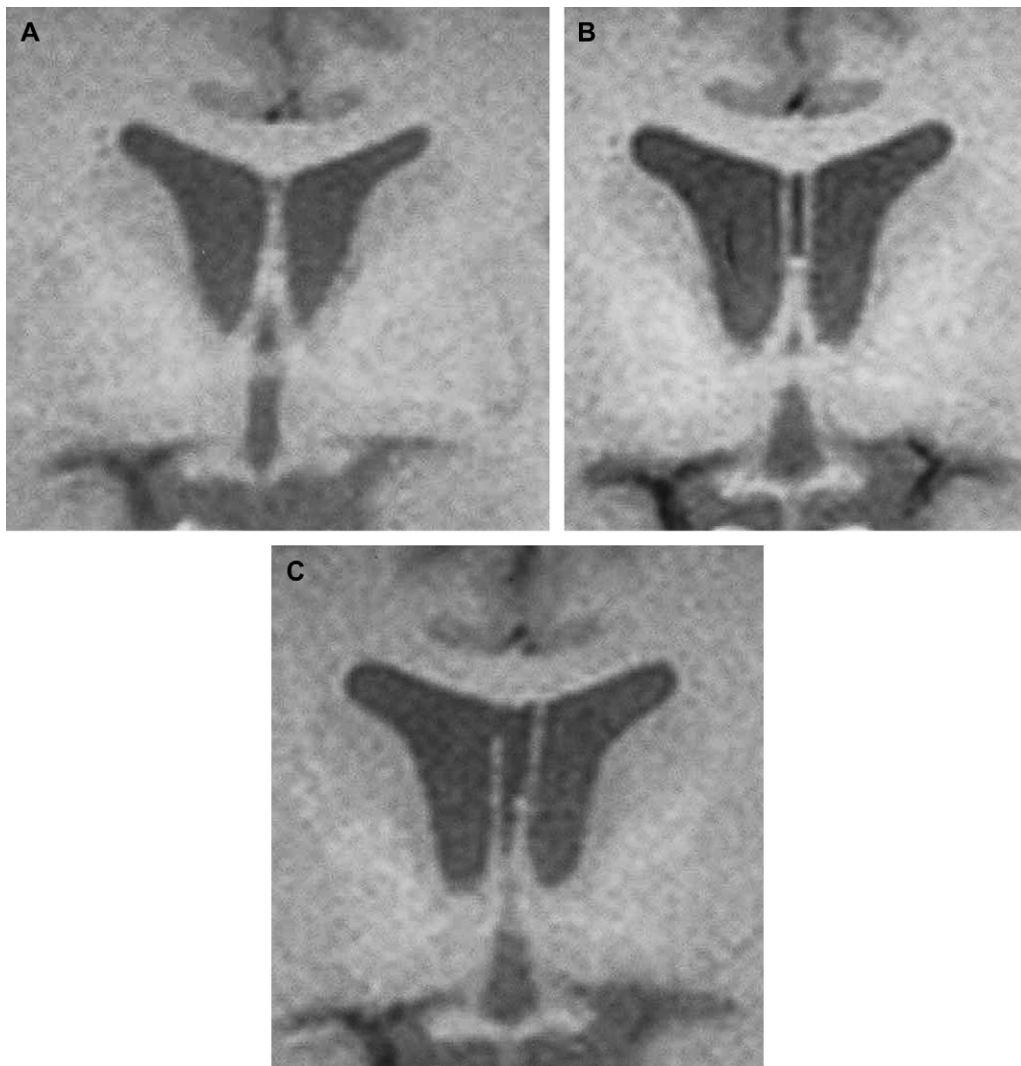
Serial coronal T1 W MRI at the level of the chiasm. (A) The initial study, dated January 29, 2000, revealed a normal study. (B) Two years later (April 29, 2002), CSP had developed. (C) One year later (May 15, 2003), the right leaflet of cavum had perforated.
